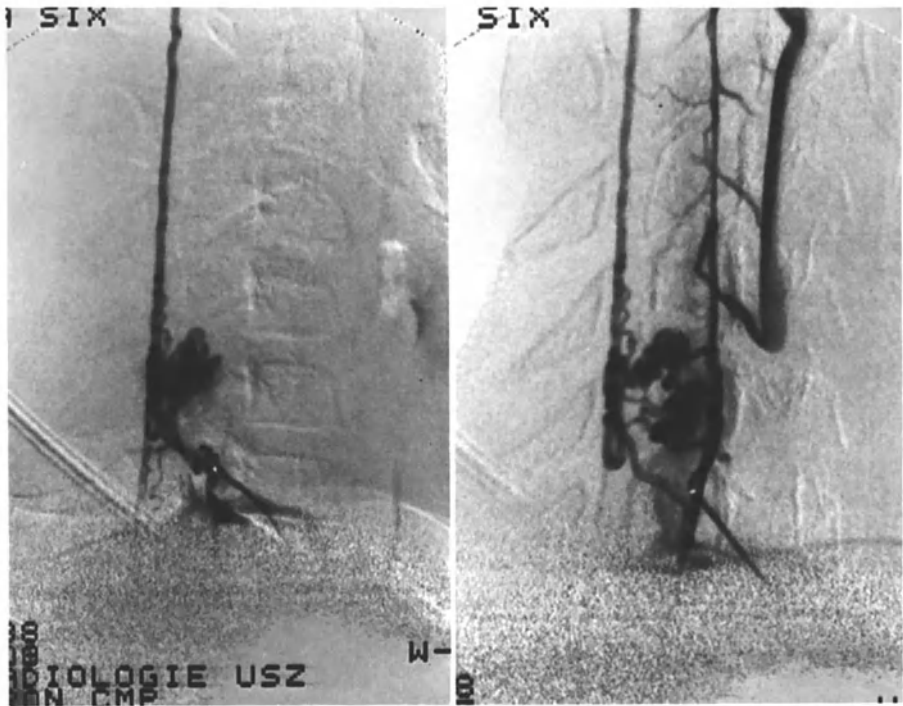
Case IV: A 12 year old girl in July of 1988 developed an acute right sided arm weakness which rapidly progressed to a dense tetraparesis. She spontaneously improved over several hours but was left with a residual torticollis. The MRI was suggestive of an arteriovenous malformation at C-4, C-5 and C-6 (A, B, C). A selective spinal arteriogram confirmed an intramedullary AVM which was considered too risky for embolization (D, E, F, G). 3 weeks later a right partial (C-4, C-5 and C-6) hemilaminectomy was performed and the lesion removed. The patient had an uneventful recovery and is without symptoms or neurologic deficits. Postoperative MRI after 2 weeks demonstrated normal spinal alignment at the operative site (H, I). No instability of vertebral column
